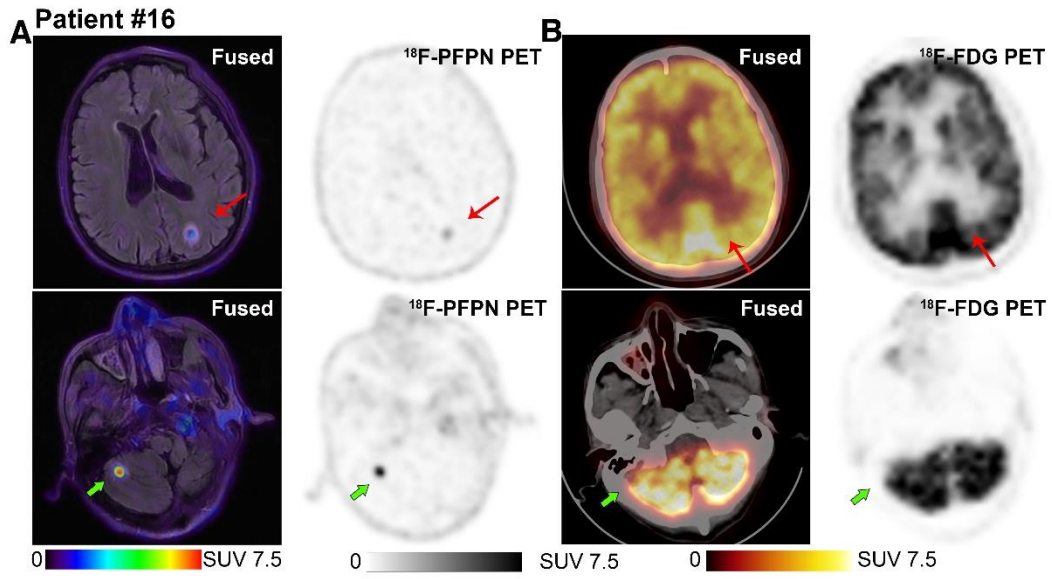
A 63-year-old man had undergone surgical removal of a plantar melanoma two years before PET imaging. Craniocerebral  $^{18}\text{F}$ -PFPN PET/MR imaging (A) revealed avid tracer uptake in the left parietal lobe (SUVmax: 1.8, red arrows) and right cerebellum (SUVmax: 4.3, green arrows). Conversely, no malignant lesions were visible on  $^{18}\text{F}$ -FDG PET; notably, these images were characterized by high background activity caused by elevated physiologic tracer uptake in the brain (B).
